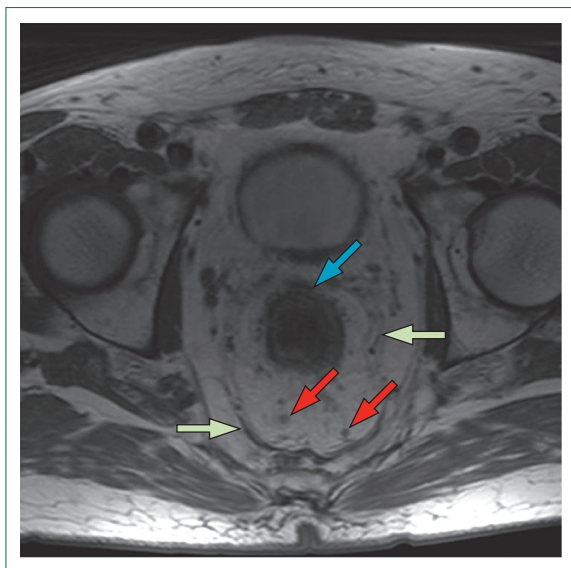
MRI of a patient with T3 rectal cancer
